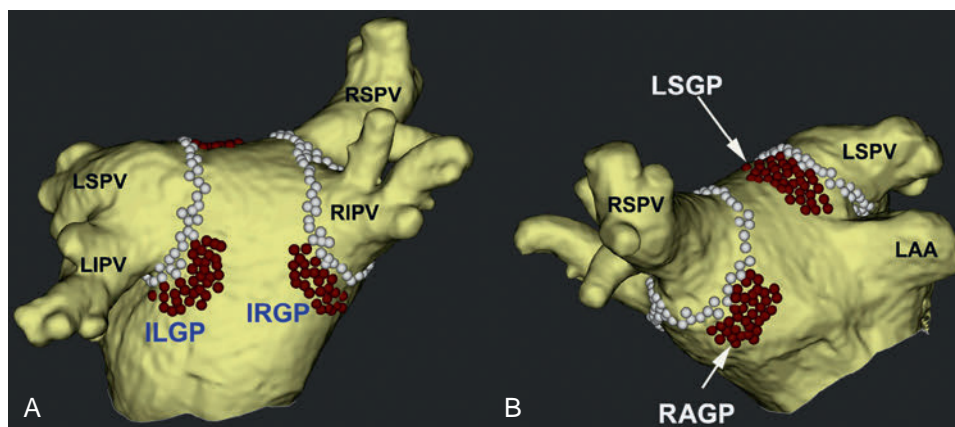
Anatomic Ablation of Left Atrial Ganglionated Plexuses (GPs). Segmented three-dimensional computed tomography of the left atrium is shown in a posteroanterior (A) and cranial right anterior oblique (B) views. Initially, circumferential antral pulmonary vein (PV) isolation is performed (*white dots*). Then, the ablation lesions were expanded (*red dots*) to cover the anatomic site of presumed GP clusters. *ILGP*, Inferior left GP; *IRGP*, inferior right GP; *LAA*, left atrial appendage; *LIPV*, left inferior PV; *LSPV*, left superior PV; *LSGP*, left superior GP; *RAGP*, right anterior GP; *RIPV*, right inferior PV; *RSPV*, right superior PV.
